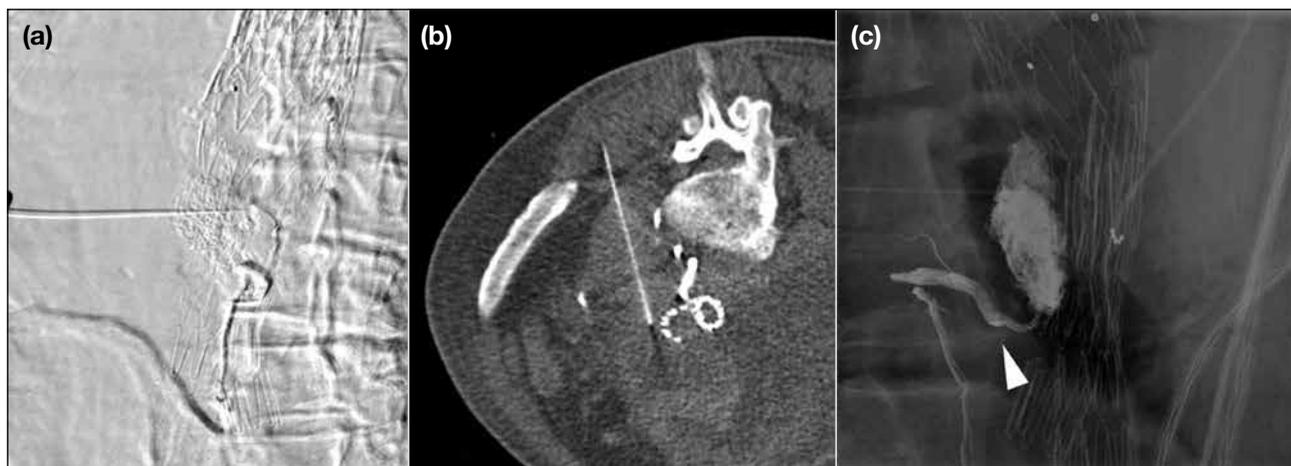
Translumbar approach/direct sac puncture. (a) Anteroposterior fluoroscopic image showing needle inserted into the aneurysm sac. (b) Computed tomography confirms needle in situ. The stent graft should be cautiously avoided. (c) Image post-embolisation using n-butyl cyanoacrylate. There is reflux into the lumbar artery (arrowhead).
